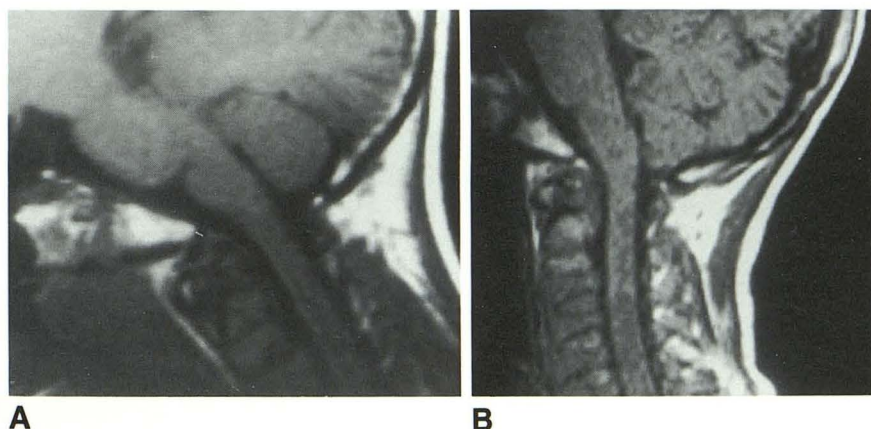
Morquio-Brailsford disease; 6-year-old boy with atlantoaxial subluxation on skull radiograph. Midsagittal T1 MR in flexion (A) and extension (B) shows mobile anterior atlantoaxial subluxation, an acquired os odontoideum, thickening of the retrodental tissues, and a minor degree of cord compression.
